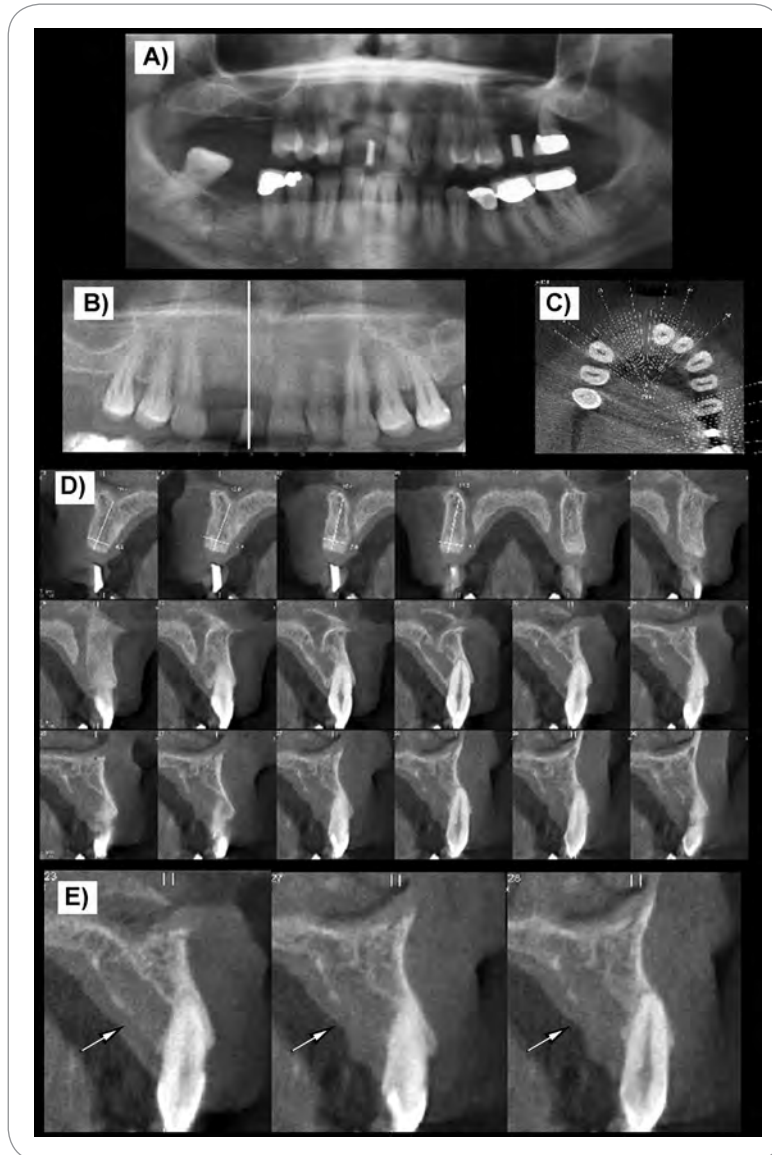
(A) Cropped conventional panoramic radiograph of patient A, prior to implant placement. Two radiopaque markers at the areas of prospective implants are in place. (B) "Panoramic" CBCT reconstruction showing the opaque marker at the area of the anterior maxilla. (C) An axial slice through the maxillary teeth showing the position and number of transaxial slices through the implant areas. (D) A series of transaxial slices through the area of teeth Nos. 8-10. Bone width and height measurements at the area of the marker demonstrate sufficient quantity and adequate quality for implant placement. Adjacent to the marker and lingual to teeth Nos. 9 and 10 an irregular radiolucency is observed. There is erosion of the palatal cortex of the maxilla with no tooth displacement and minimal bone expansion. (E) Selected magnified transaxial sections through the area of the lesion. This radiographic presentation is consistent with malignant disease or infection. Biopsy of the lesion demonstrated metastatic malignancy of unknown origin.
